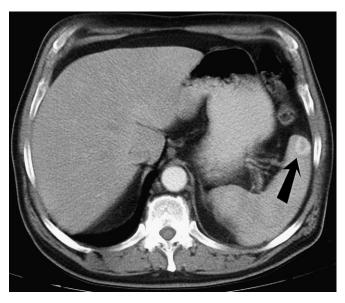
A 60-year-old man who underwent nephrectomy for renal cell carcinoma 8 years earlier. Arterial phase of contrast-enhanced computed tomography, demonstrating enhancing metastasis in the spleen (black arrow).
